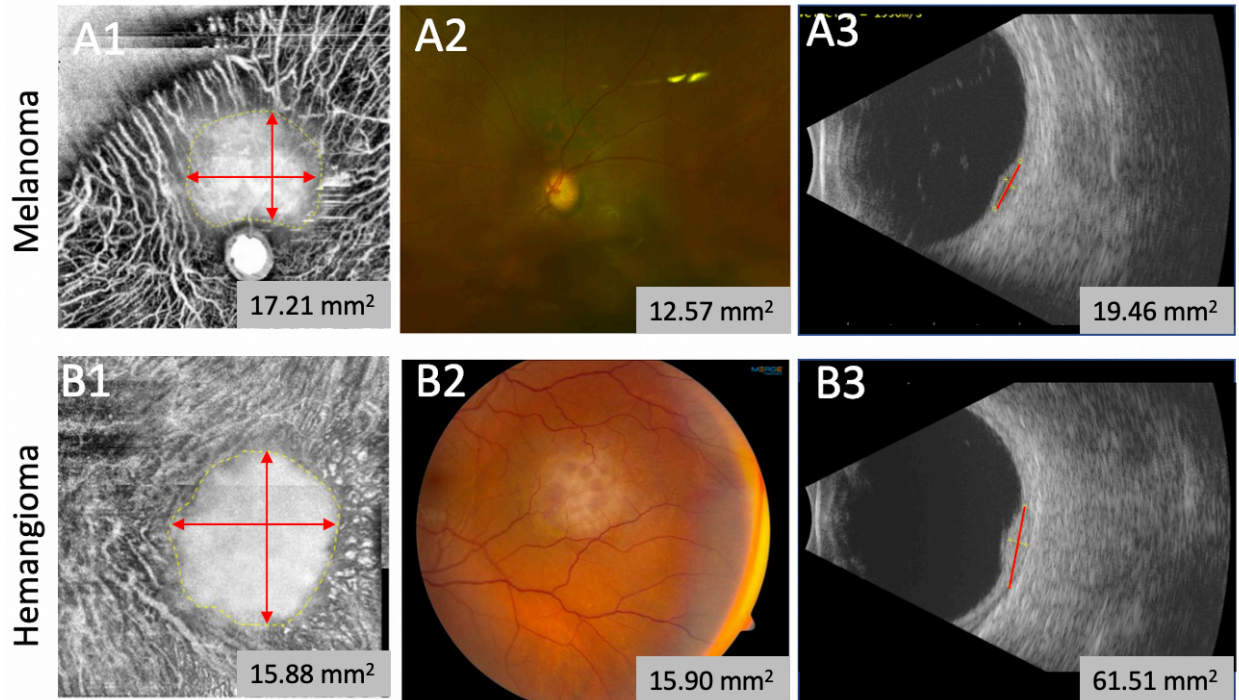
En face SS-OCT image of a choroidal melanoma with lesion boundary depicted as the yellow dash line and maximum horizontal and trasverse inner diameter depicted as red arrow line (A1) or hemangioma (B1). A2, B2: Color fundus. A3, B3: Ultrasound B-scan with base measurement in red.
